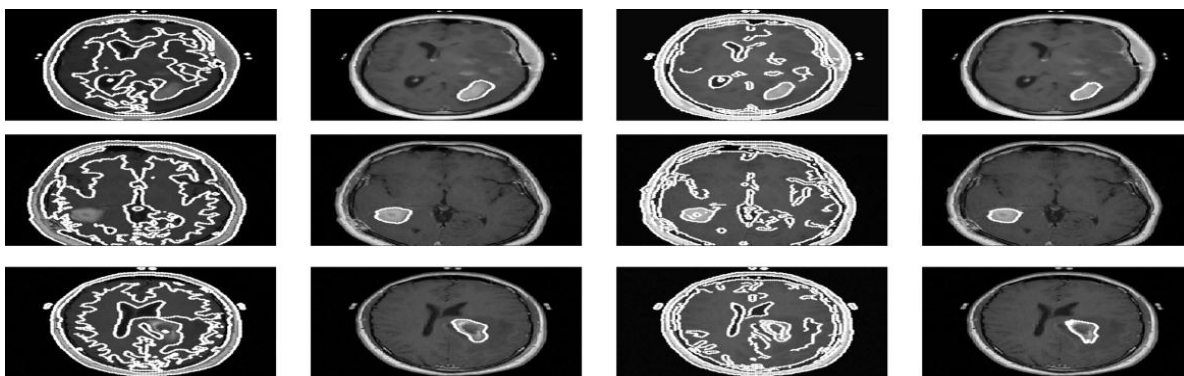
Tumour detection from T1C axial brain MRI slices. From left: first column, results of the Chan–Vese algorithm; second column, results of Chan–Vese algorithm within bounding box; third column, results of the normalized graph-cut algorithm; fourth column, results of the normalized graph-cut algorithm within bounding box.
